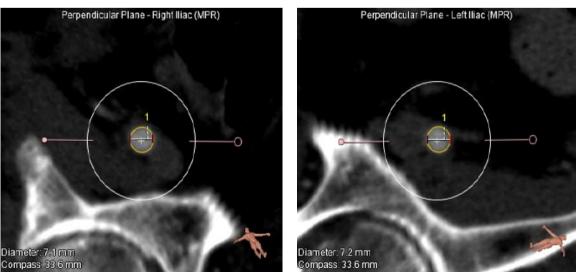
Figure CTA-10: Example of the peripheral vessels and measurements for the right (left) and left (right) iliac arteries.
